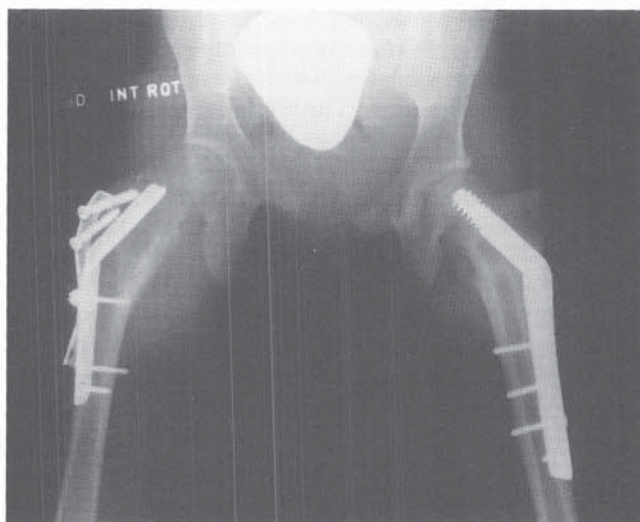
Postoperative radiograph following valgus osteotomy of the proximal femurs performed on the child whose pretreatment radiograph is shown in Figure 29–76.
